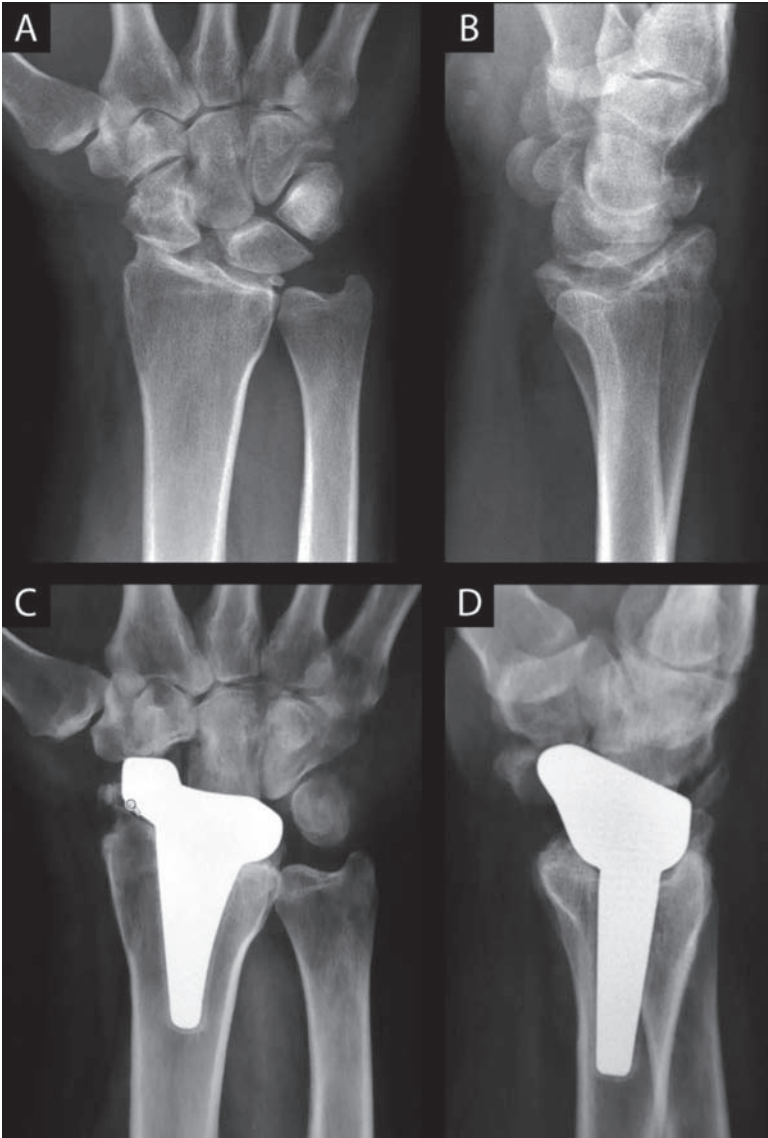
Radiographs demonstrating the use of a prosthesis specifically designed to accommodate the anatomy of the distal carpal row. This 41-year old male active right-hand dominant male was treated for severe radiocarpal arthritis (A, B) using a midcarpal hemiarthroplasty implant, and followup radiographs were obtained one year after surgery (C, D). Note the preservation of carpal height with the use of a midcarpal hemiarthroplasty. The patient was able to resume golfing on a regular basis 12 weeks post-operation.
